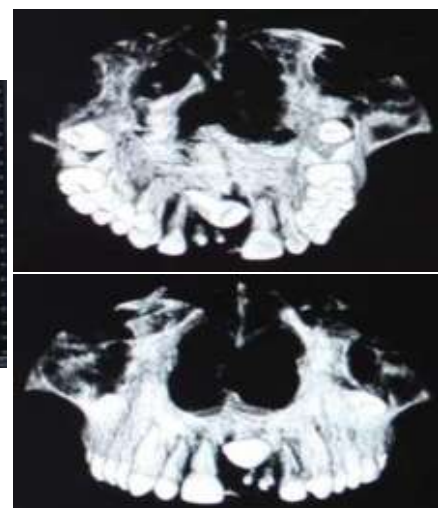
Pre Treatment CBCT
